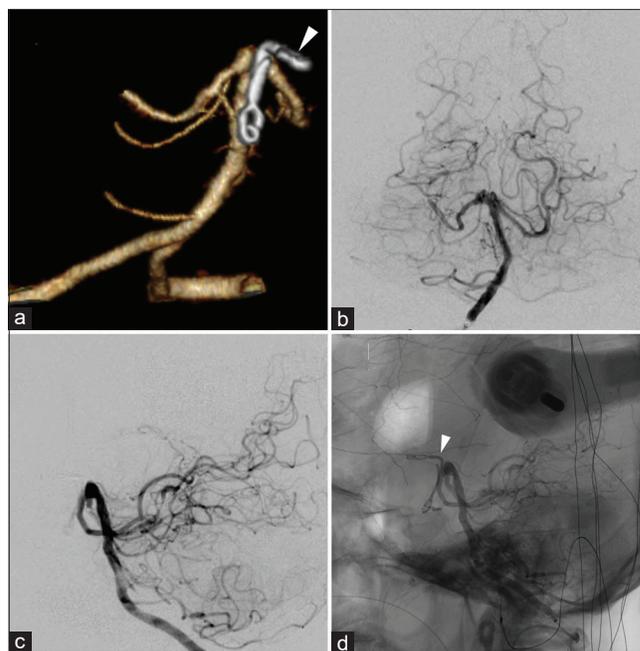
Postoperative images. (a) Postoperative three-dimensional computed tomography angiogram; (b-d) postoperative digital subtraction angiogram showing the presently applied clip (arrow).
